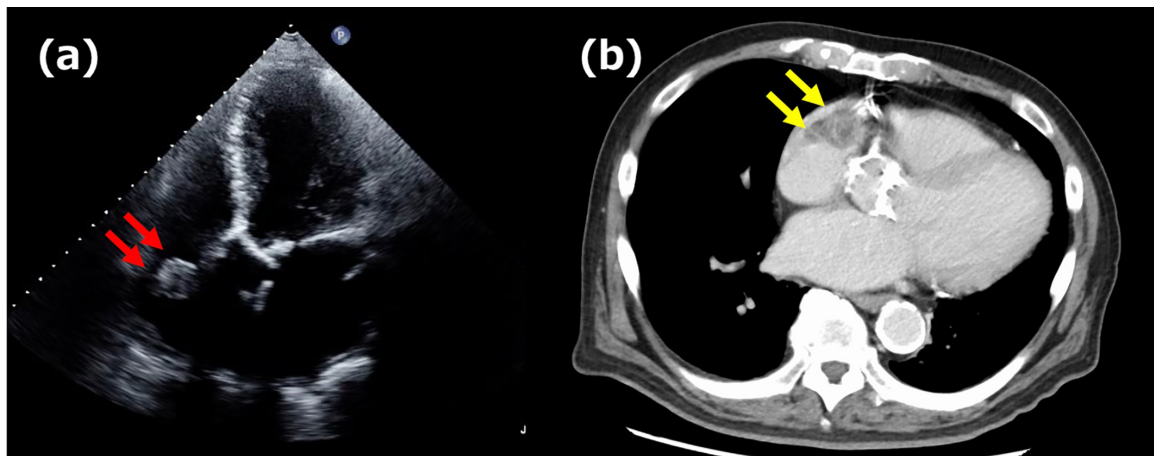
Image findings of the tumor. (a) Transthoracic echocardiographic image, red arrows indicate the tumor in the right atrium. (b) CT image, Yellow arrows indicate the tumor in the right atrium. CT, computed tomography.
